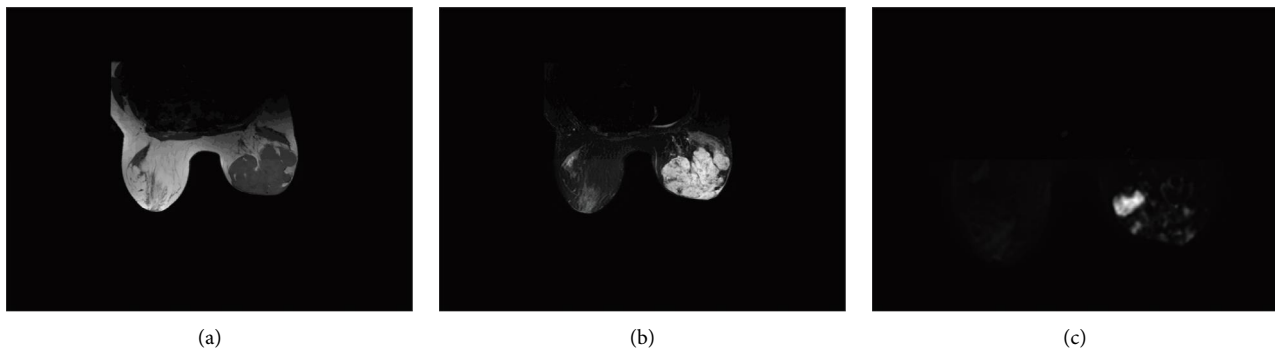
Breast MRI of a 19-year-old girl with primary breast angiosarcoma of the right breast. (a) T1-weighted image revealed multiple fused masses with slight hypointense. (b) Hyperintense in fat-suppressed T2-weighted sequence. (c) Diffusion-weighted image demonstrated a high signal.
